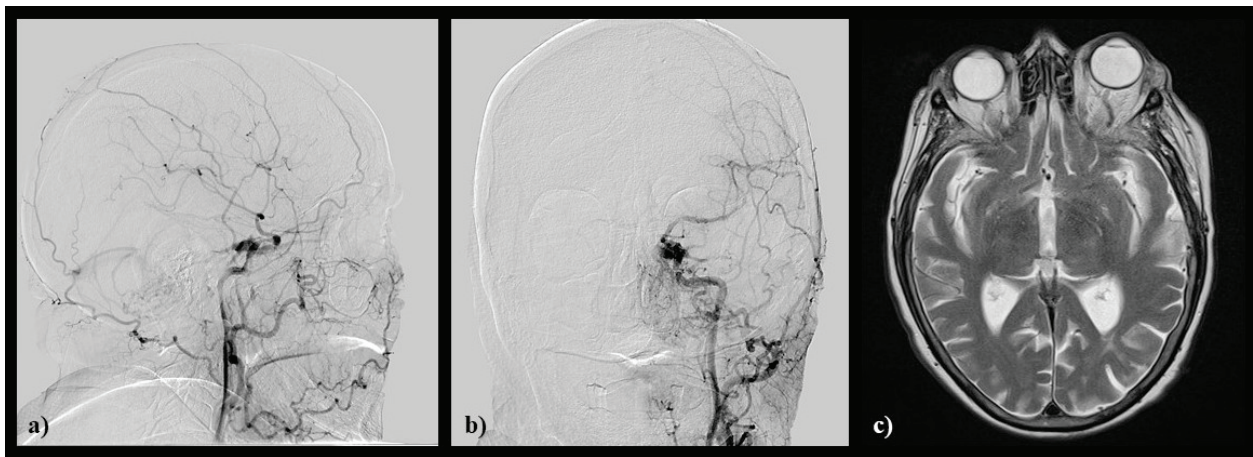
Preoperative images: a) preprocedural DSA showing CCF with dilatated and retrogradely filled SOV, along with outflow from CCF to dilatated cortical cerebellar veins (LL projection), b) preprocedural DSA showing CCF with dilatated and retrogradely filled SOV, along with outflow from CCF to dilatated cortical cerebellar veins (AP projection), and c) MRI T2-sequence showing dilatated SOV on the left side with proptosis of the eye.
